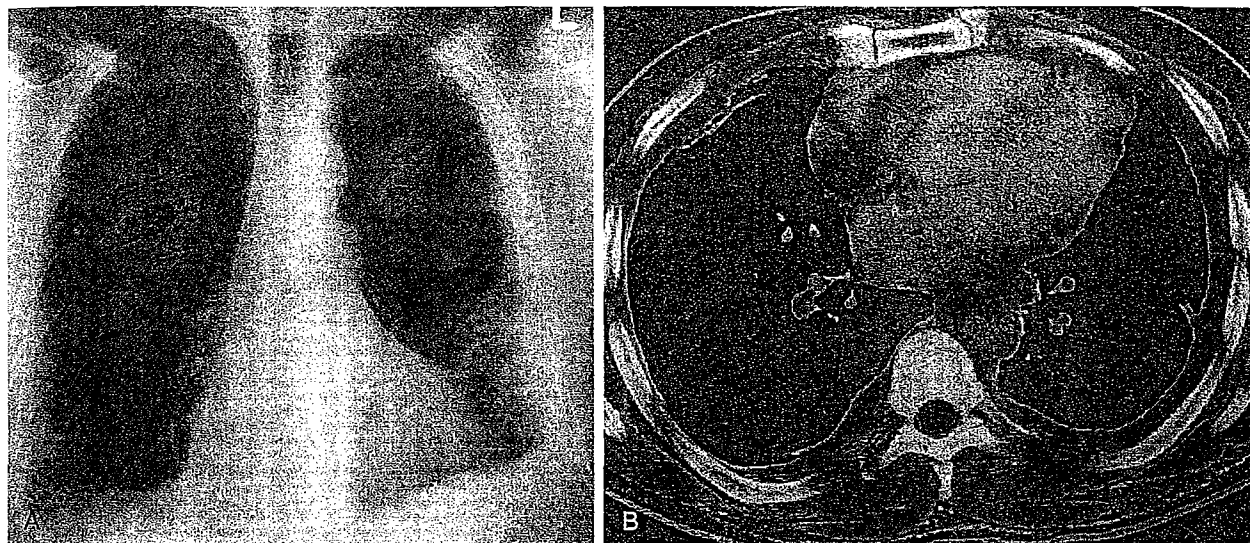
Diffuse Asbestos-Related Pleural Thickening. A 47-year-old cement worker presented with progressive shortness of breath. A posteroanterior chest radiograph (A) demonstrates diffuse bilateral pleural thickening as well as blunting of the costophrenic sulci. Curvilinear opacities extending to the thickened pleura are present in the left lung. An HRCT scan (B) confirms the presence of marked pleural thickening. The inner margin of the thickened pleura is irregular because of areas of fibrosis or atelectasis in the adjacent lung. Despite the extensive pleural thickening in the paravertebral portion of the pleura and lateral chest wall, there is no evidence of involvement of the mediastinal pleura.
